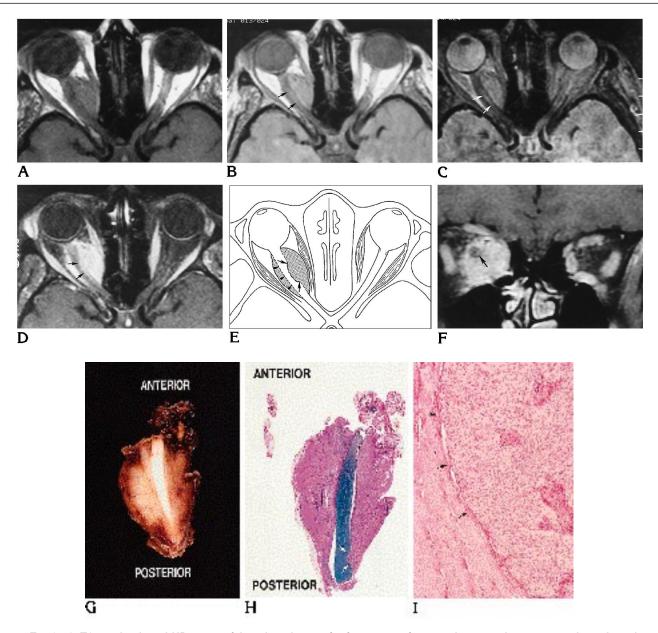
A*, T1-weighted axial MR image of the orbits shows a fusiform mass of intermediate signal intensity involving the right intraorbital optic nerve. The mass encroaches on the medial rectus muscle. Mild right proptosis is present.
